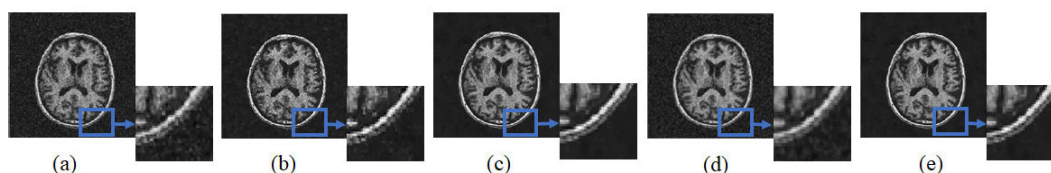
Denoising by different algorithms on real 2D MRI brain scans [46]: (a) CNN-RL [35], (b) RED-CNN [34], (c) K-SVD [22], (d) BM3D [58], and (e) Proposed 2D.
